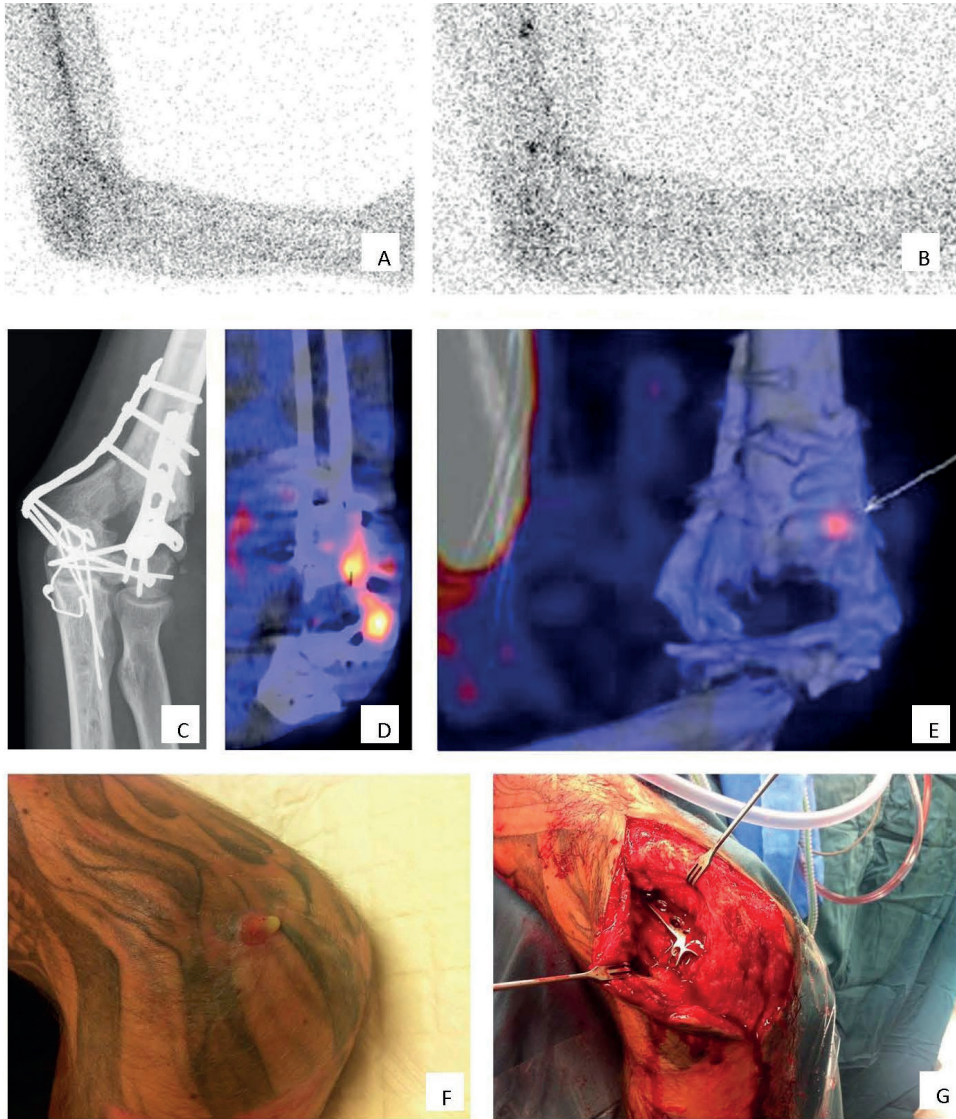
Clinical example WBC-scintigraphy + SPECT/CT. A 37 year old man with a grade 3A complicated distal humeral fracture of the left elbow, initially treated with an external fixator and subsequently by plate osteosynthesis of the distal humerus. C X-ray: situation after recent fixation of the fracture with plate osteosynthesis, no signs of loosening or infection. After 4 months, he presented with a fistula and a clinical suspicion of osteomyelitis of the distal humerus. A-B, D-E: WBC scintigraphy (A image at 4 hours, B image at 24 hours, D-E fusion SPECT/CT images) after the injection of 220 MBq ^{99m}Tc -labeled leucocytes demonstrated an infection around the implant at the lateral side of the elbow/distal screw. The low uptake points to an only low grade appearance and the location to soft tissue involvement, this was confirmed at operation (F clinical pre-operative picture G perioperative clinical picture).
